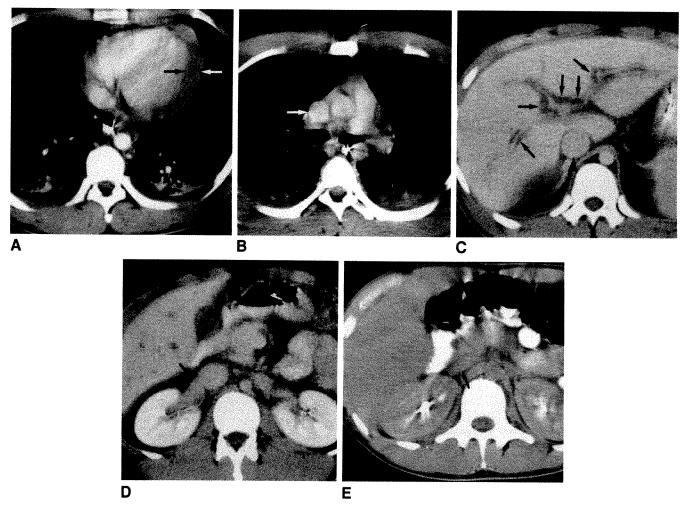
CT of pericardial tamponade.
